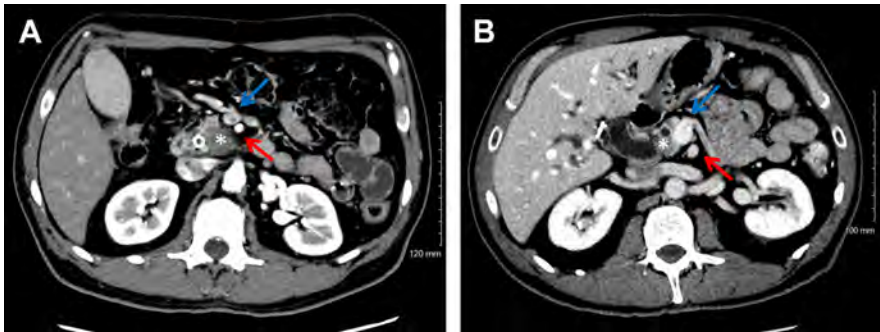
Computed tomography axial images of resectable pancreas cancer. (A) Tumor in the uncinate process of the pancreas (*asterisk*); a fat plane is present between the tumor and the superior mesenteric artery (SMA, *red arrow*), and the SMV (*blue arrow*). (B) There is less than 50% lateral tumor abutment of the SMV and no extension to the SMA.
